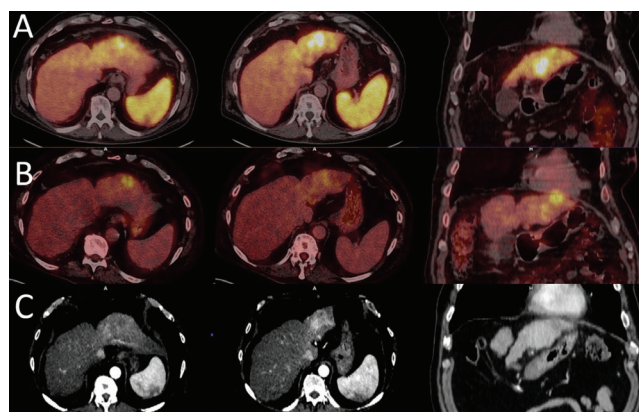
A 67-year-old cirrhotic male with hepatocellular carcinoma in the left lobe of the liver. ⁶⁸Ga-PSMA: (A) SUV_{max}: 28.1; T/L: 3.95; T/G: 31.2. ¹⁸F-FDG: (B) SUV_{max}: 10.1; T/L: 2.76; T/G: 7. In arterial phase CT images (C), it is seen that PSMA uptake is higher in the hyperenhancement areas and ¹⁸F-FDG uptake is higher in the non-enhancing areas of the tumor
